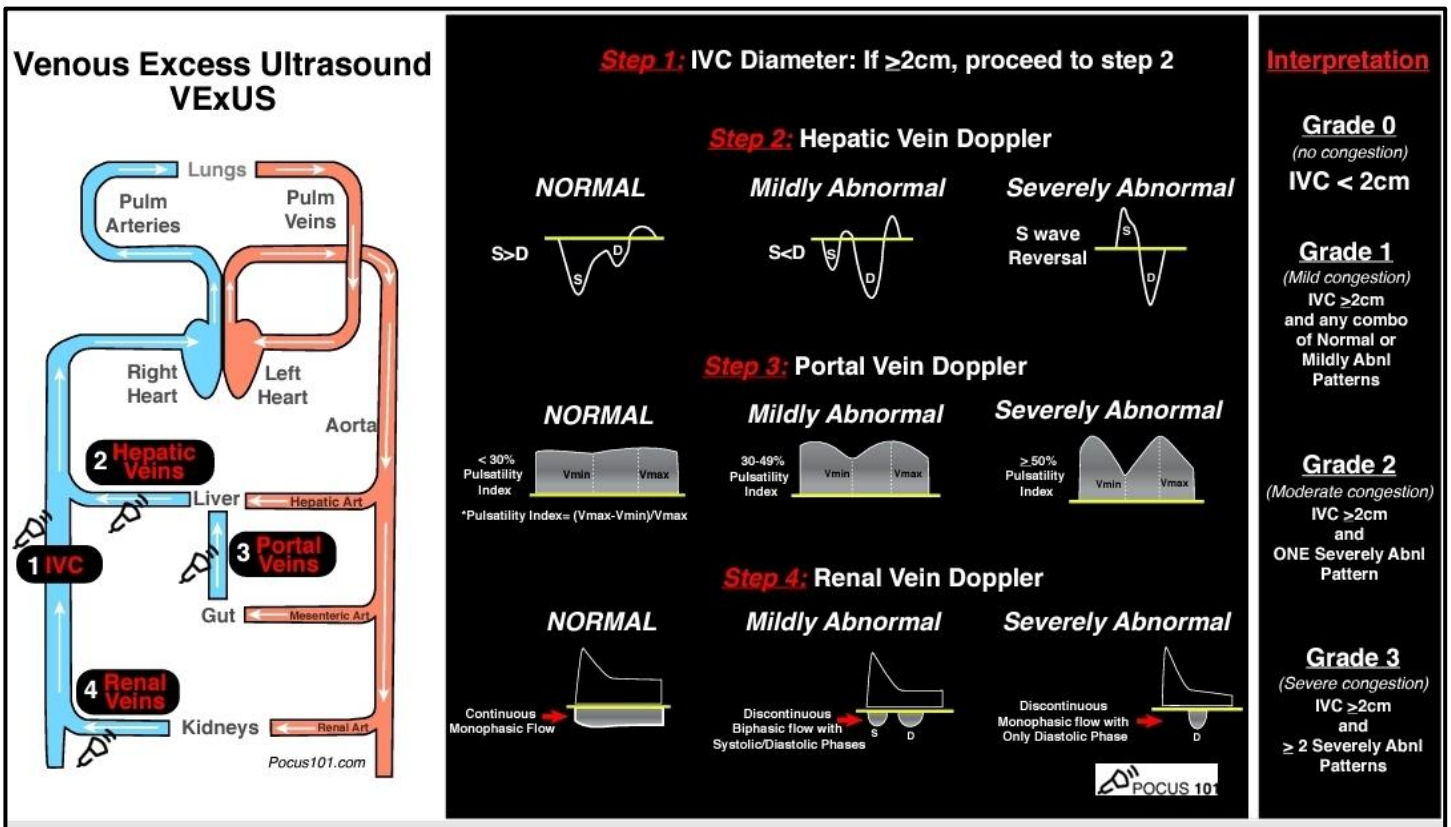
VExUS Ultrasound Score and doppler waves characteristics according to volume congestion severity.
